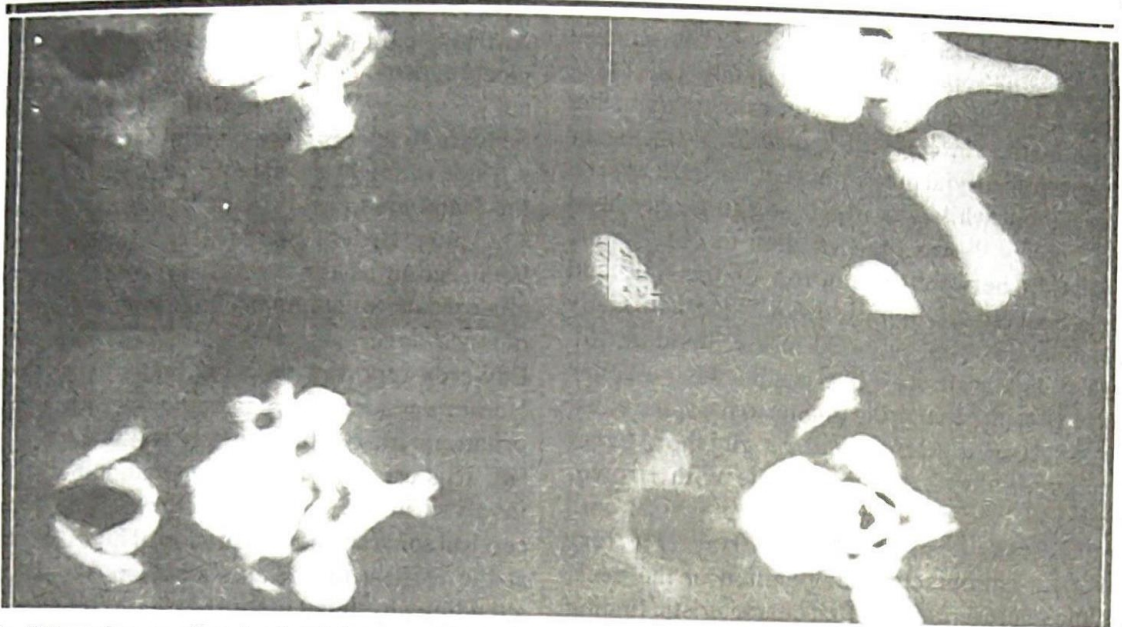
CT myelogram showing levels between C5 - T1
